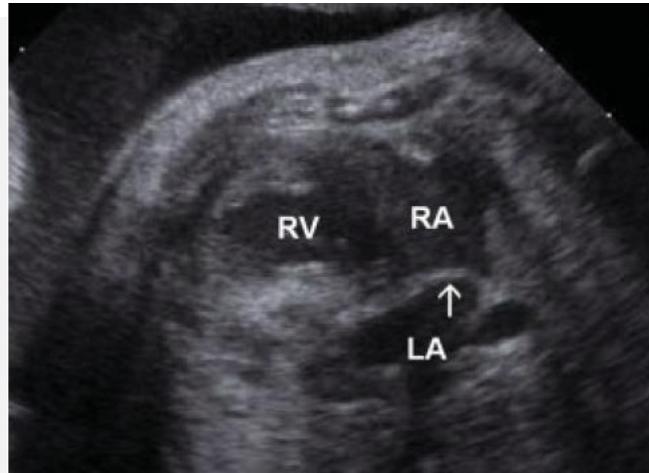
Top panel: Hypoplastic left heart syndrome with intact atrial septum at 31 weeks gestational age. Severe left ventricular hypoplasia is noted. The left atrium is markedly dilated, and the thickened, hypertrophied septum primum (arrow) bulges into the right atrium. Middle panel: An inflated angioplasty balloon traverses the right atrium, atrial septum and into the left atrium. Bottom panel: Still-frame color Doppler image demonstrating a jet of left-to-right flow (asterisk) across the newly created atrial septal defect. LA, left atrium; RA, right atrium; RV, right ventricle.
